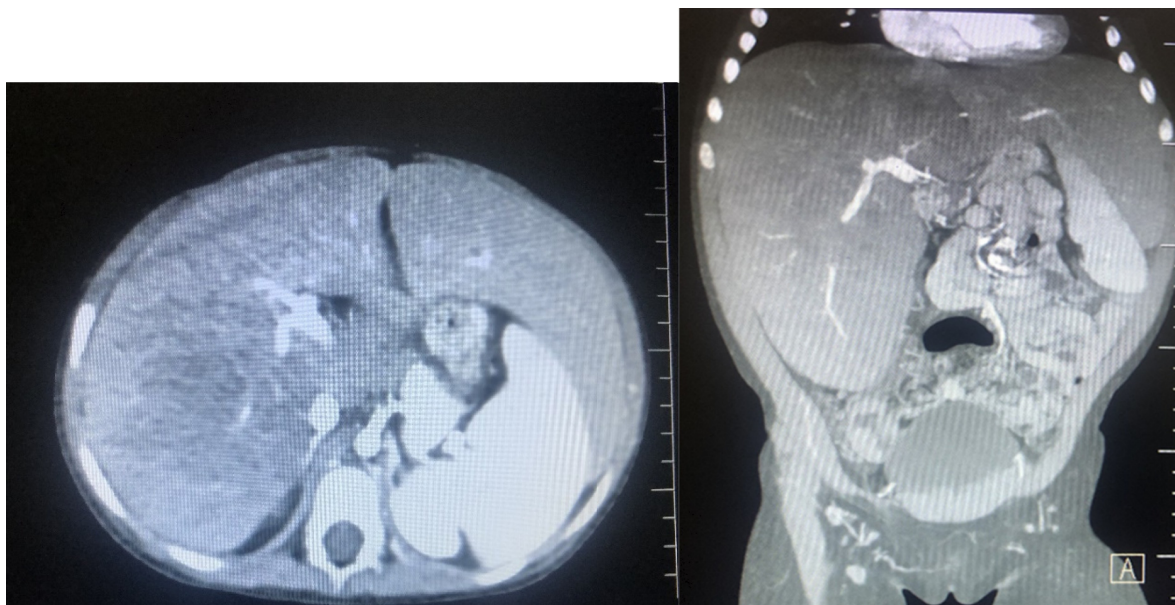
Abdomen CT with contrast dye shows excess hepatosplenomegaly, with heterogenous hypodense lesions in liver. CT, computed tomography.
